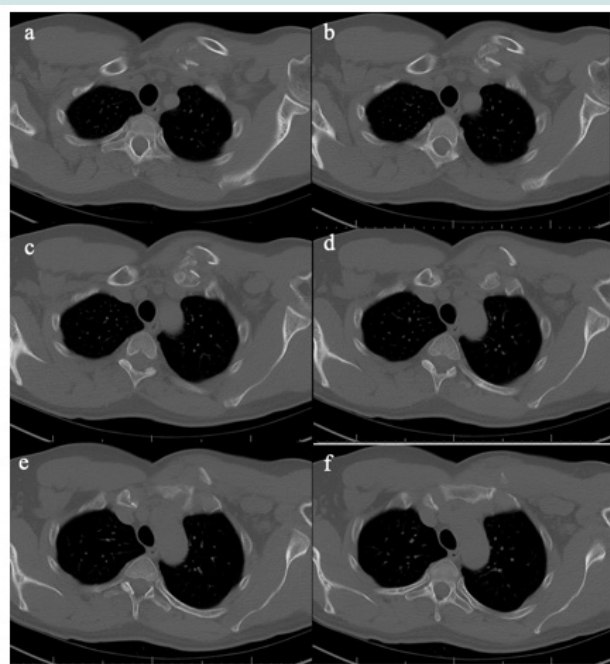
Cranial to caudal axial cuts (a-f) of the chest CT taken the day of the injury showing a left comminuted medial clavicle fracture with intra-articular involvement and anterior displacement of the clavicle relative to the sternum.
